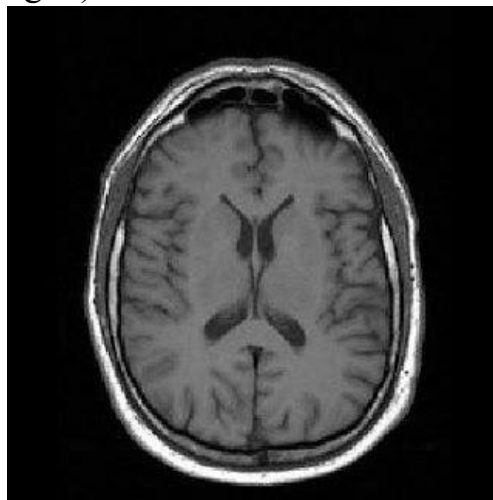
Axial T1-weighted MR image of the human brain
